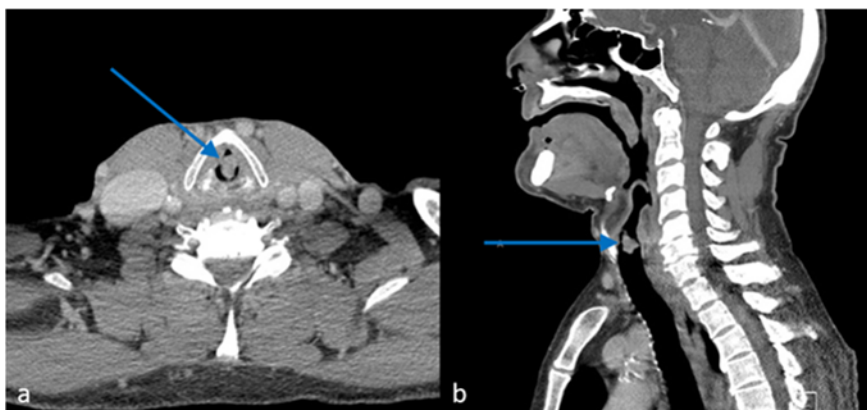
Axial (a) and sagittal (b) CT of the neck with contrast demonstrate a vocal cord polyp (blue arrow) protruding into the larynx from the right true vocal cord. The patient had a long history of smoking and alcohol use with worsening hoarseness of the voice. The patient was hospitalized in respiratory distress. The polyp caused a ball valve effect making expiration progressively more difficult. Pathology revealed a squamous cell carcinoma. After excision, breathing returned to normal and hoarseness significantly improved. Image courtesy of University of Massachusetts Medical School, Department of Radiology.
